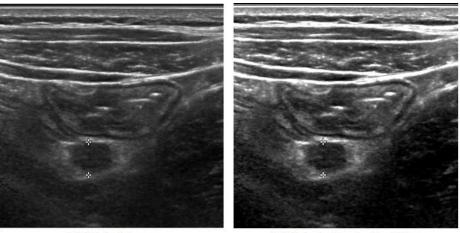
Abdomen Ultrasound DICOM Image
